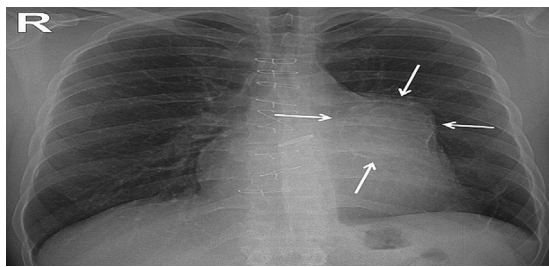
Chest X-ray showed enlargement and peripheral calcification of the left lateral border on the cardiac silhouette (arrows). LV, left ventricle.
